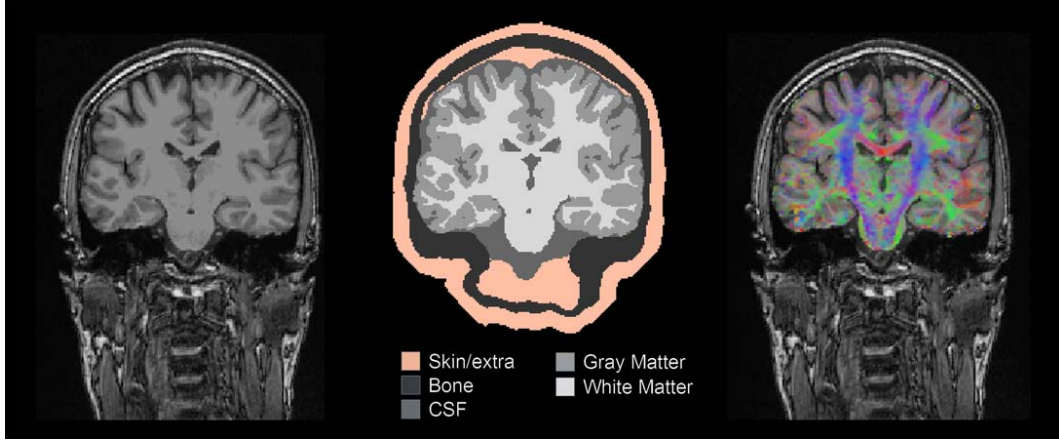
From left to right: coronal section of the T1-weighted data set; same slice after segmentation into five different tissue types, diffusion tensor data visualized by color-coded representation of the first principal component (largest eigenvector), registered and overlaid on the T1-weighted slice.
